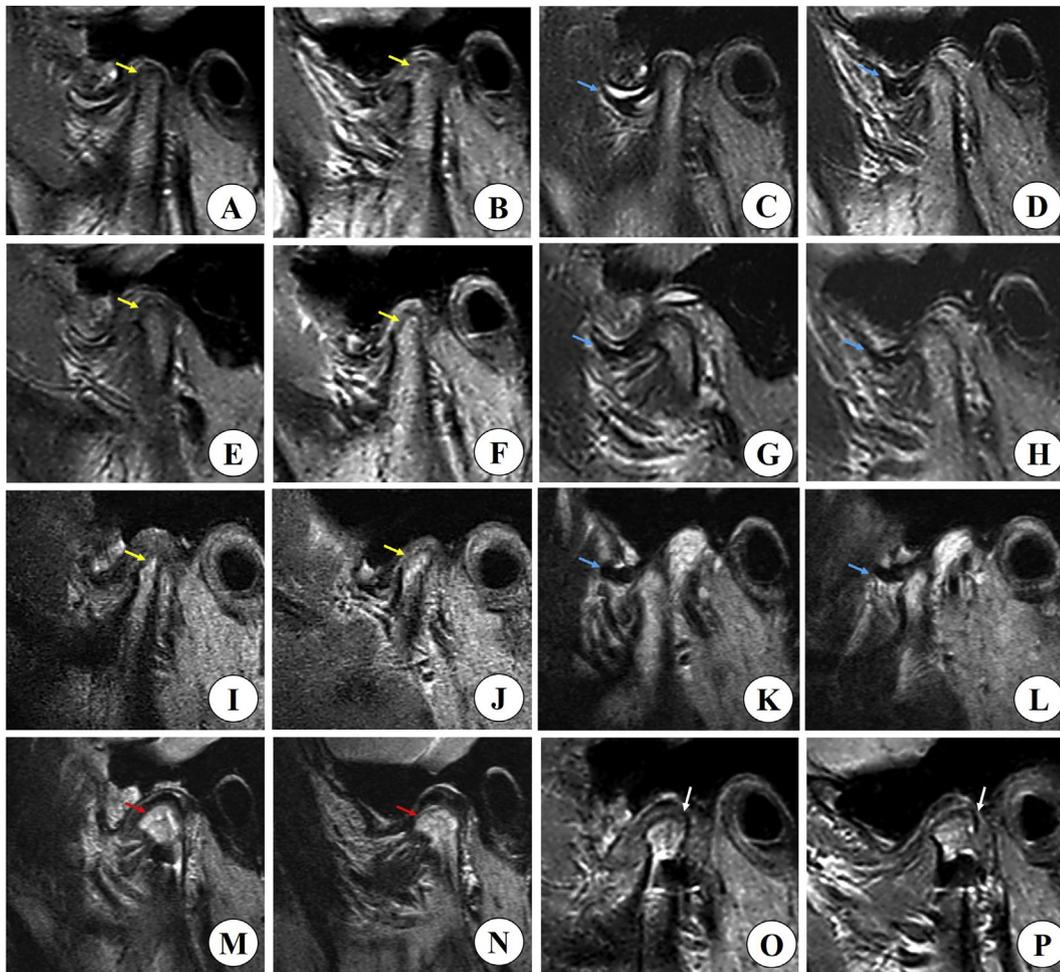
Male, 14 years old, treated by disc repositioning and post-operative functional splint. Condyle changes before and after disc repositioning by MRI. A, B, discontinuous bone cortex (yellow arrows) of right and left sides at initial visit in closing position; C, D, anterior displaced disc without reduction (blue arrows) in opening position at initial visit; E–L, 6 months (E–H) and 1 year follow-ups (I–L): degenerative remodeling on condylar head (yellow arrows), further shortened and distorted discs (blue arrows); M, N, 3 months after treatment: new bone formation were observed (red arrows). O, P, 6 months after treatment: gradually regenerated bone cortex (white arrows).
